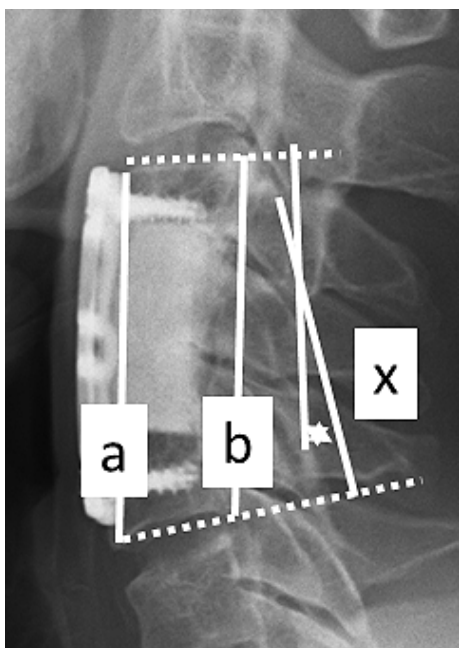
Postoperative radiograph showing the fused segment angle and fused segment height. Fused segment angle is the angle between lines drawn parallel to the cranial endplate of the cranial vertebra of the fused segment and the caudal endplate of the caudal vertebra of the fused segment (x). Fused segment height is the mean value of the anterior and posterior vertebral body heights at the fused segments $((a+b)/2)$.
